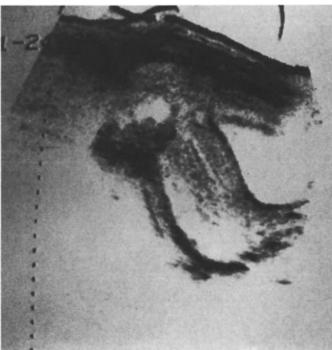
Ultrasound scans of a 6-week fetus, a 9-week fetus, and an ectopic pregnancy. Note the presence of a gestational sac in the uterine pregnancies.
